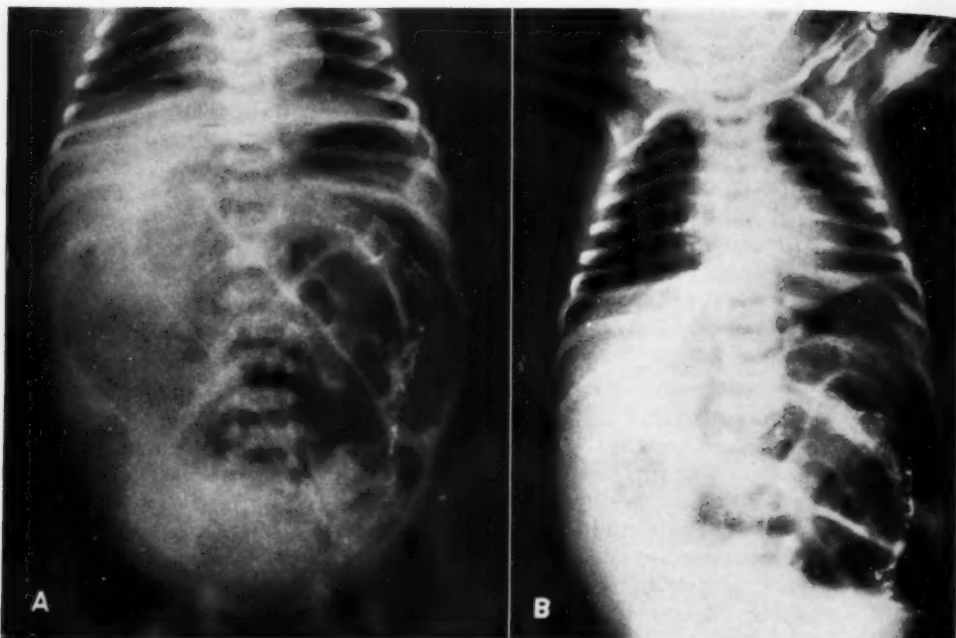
Case I. Supine (A) and upright (B) roentgenograms of abdomen at the age of twenty-six hours in uncomplicated meconium ileus. Dilated loops of small bowel with no fluid levels are evident in the upright position.
